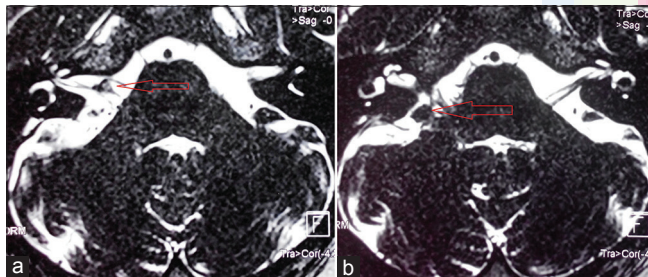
(a) Axial section of T2 constructive interference in steady-state - magnetic resonance imaging showing tri-radiate appearance (red arrow) of clumped anterior inferior cerebellar artery, 7th and 8th nerve in right cerebellopontine angle cistern. (b) Axial section of T2 constructive interference in steady-state - magnetic resonance imaging showing hypodense round lesion (?Teflon graft) (red arrow) adhered to 7th-8th nerve complex
